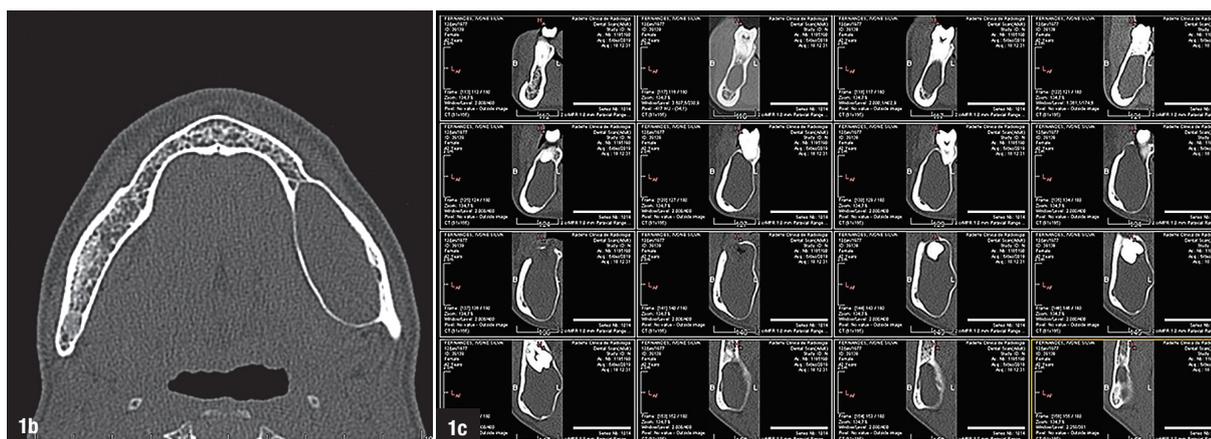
Initial CT sagittal section. Fig. 1c: Initial CT cross section.
